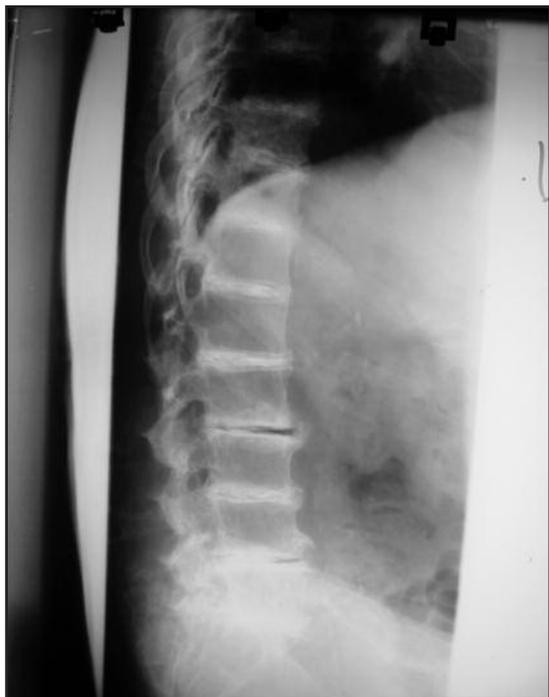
Lumbosacral spine X-ray
